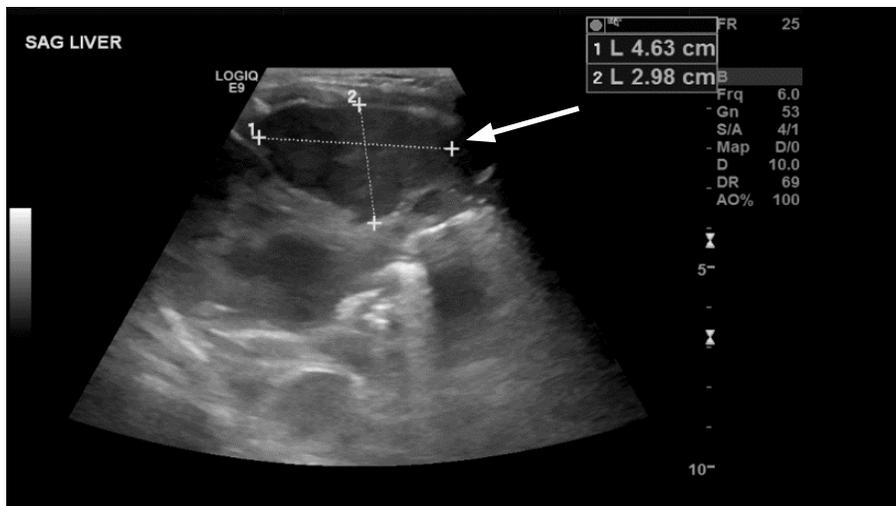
Hepatic ultrasound, sagittal view, obtained at admission with a hemangioma measuring 4.63 x 2.98 cm (arrow).
